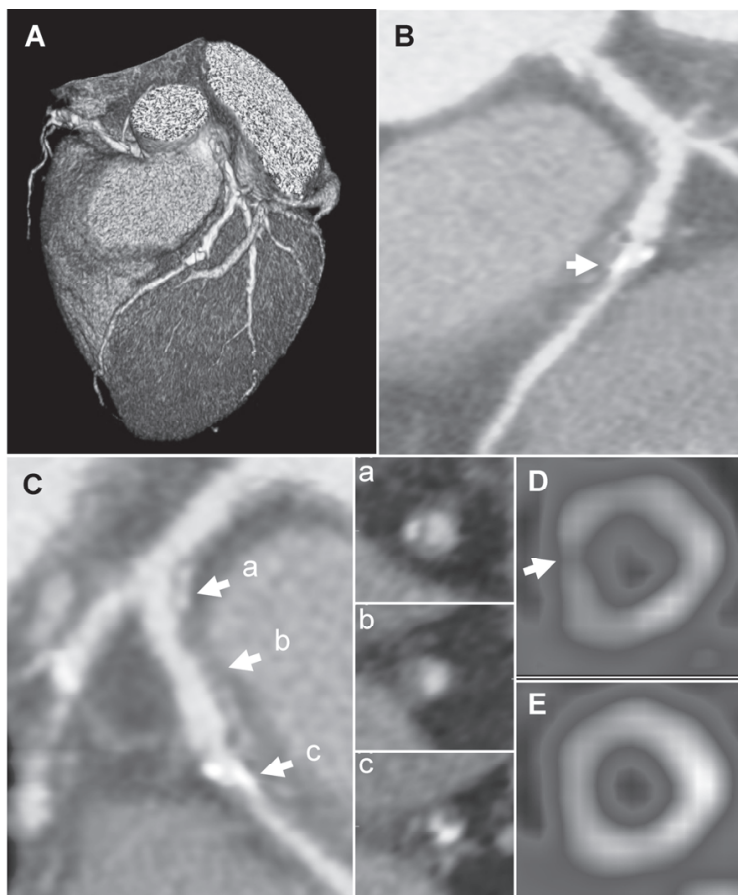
Example of a 72 year-old male patient exhibiting all the significant predictors on multislice computed tomography (MSCT) for prediction of ischemia on myocardial perfusion imaging (MPI). In panel A, a 3D volume rendered reconstruction is provided, showing the left anterior descending coronary artery (LAD). Panel B: A curved multiplanar reconstruction (MPR) of the LAD is shown demonstrating the presence of obstructive CAD ($\geq 50\%$) in the proximal segment (arrow). Panel C: Another curved MPR of the LAD is shown in a different view, revealing the presence of multiple diseased segments (cross sectional images a, b and c), the presence of obstructive lesion in the LAD (arrow c) and the presence of mixed plaque (cross sectional images a, b and c). Panel D: Stress single photon emission computed tomography (SPECT) short axis image showing the presence of a perfusion defect, particularly evident in the antero-septal region (arrow). Panel E: Rest SPECT short axis image demonstrating normal perfusion.
